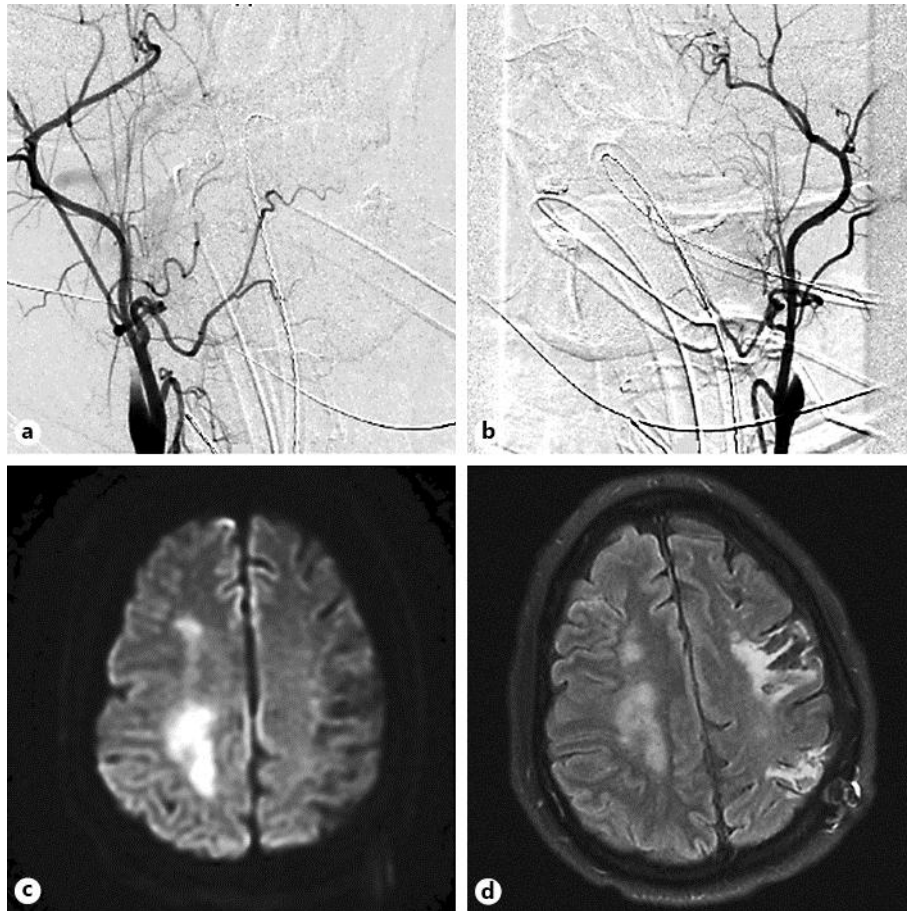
Angiogram shows occlusions of the right (a) and left (b) internal carotid arteries in the proximal cervical segments. Infarction in the right middle cerebral artery-anterior cerebral artery watershed territory is seen on the DWI image (c). The T2 FLAIR image (d) shows the same area of infarction in the right middle cerebral artery-anterior cerebral artery watershed territory as well as regions of chronic infarction in the left middle cerebral artery territory.
